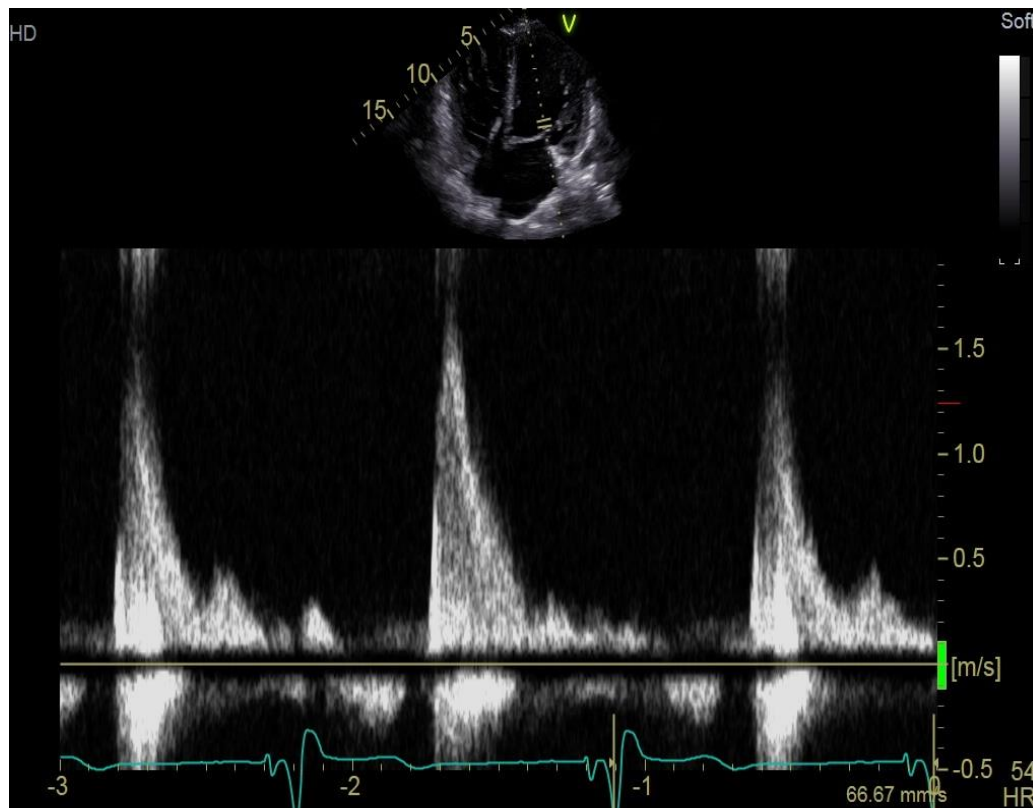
Pulsed wave Doppler of mitral inflow.
